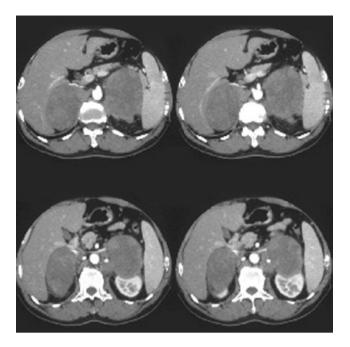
Enhanced CT scan of adrenals.
